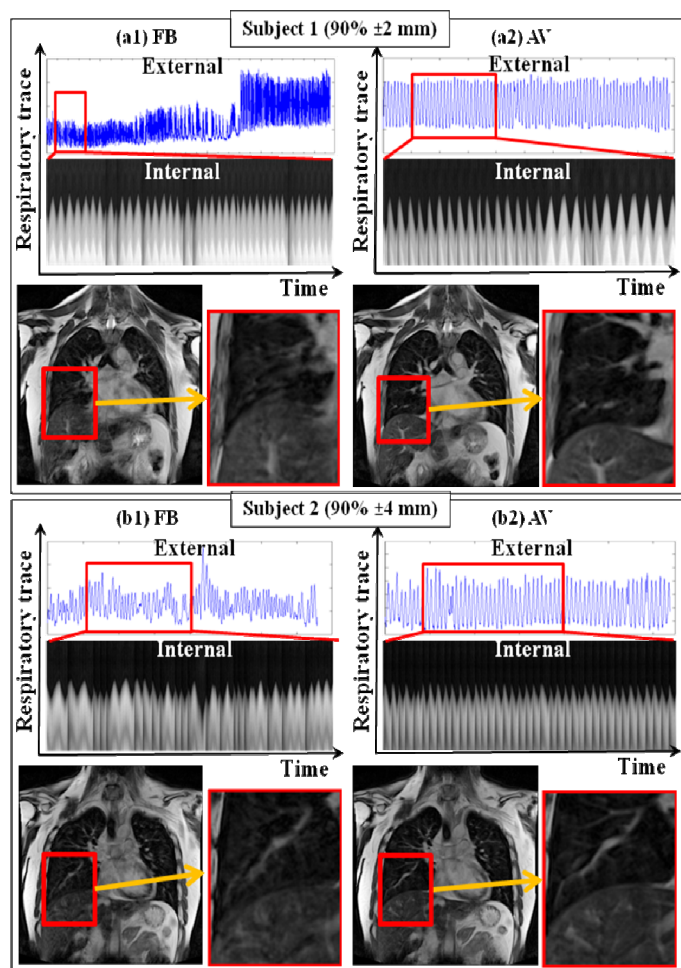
An example of improvement when AV biofeedback was employed during gated 3D MR imaging.
